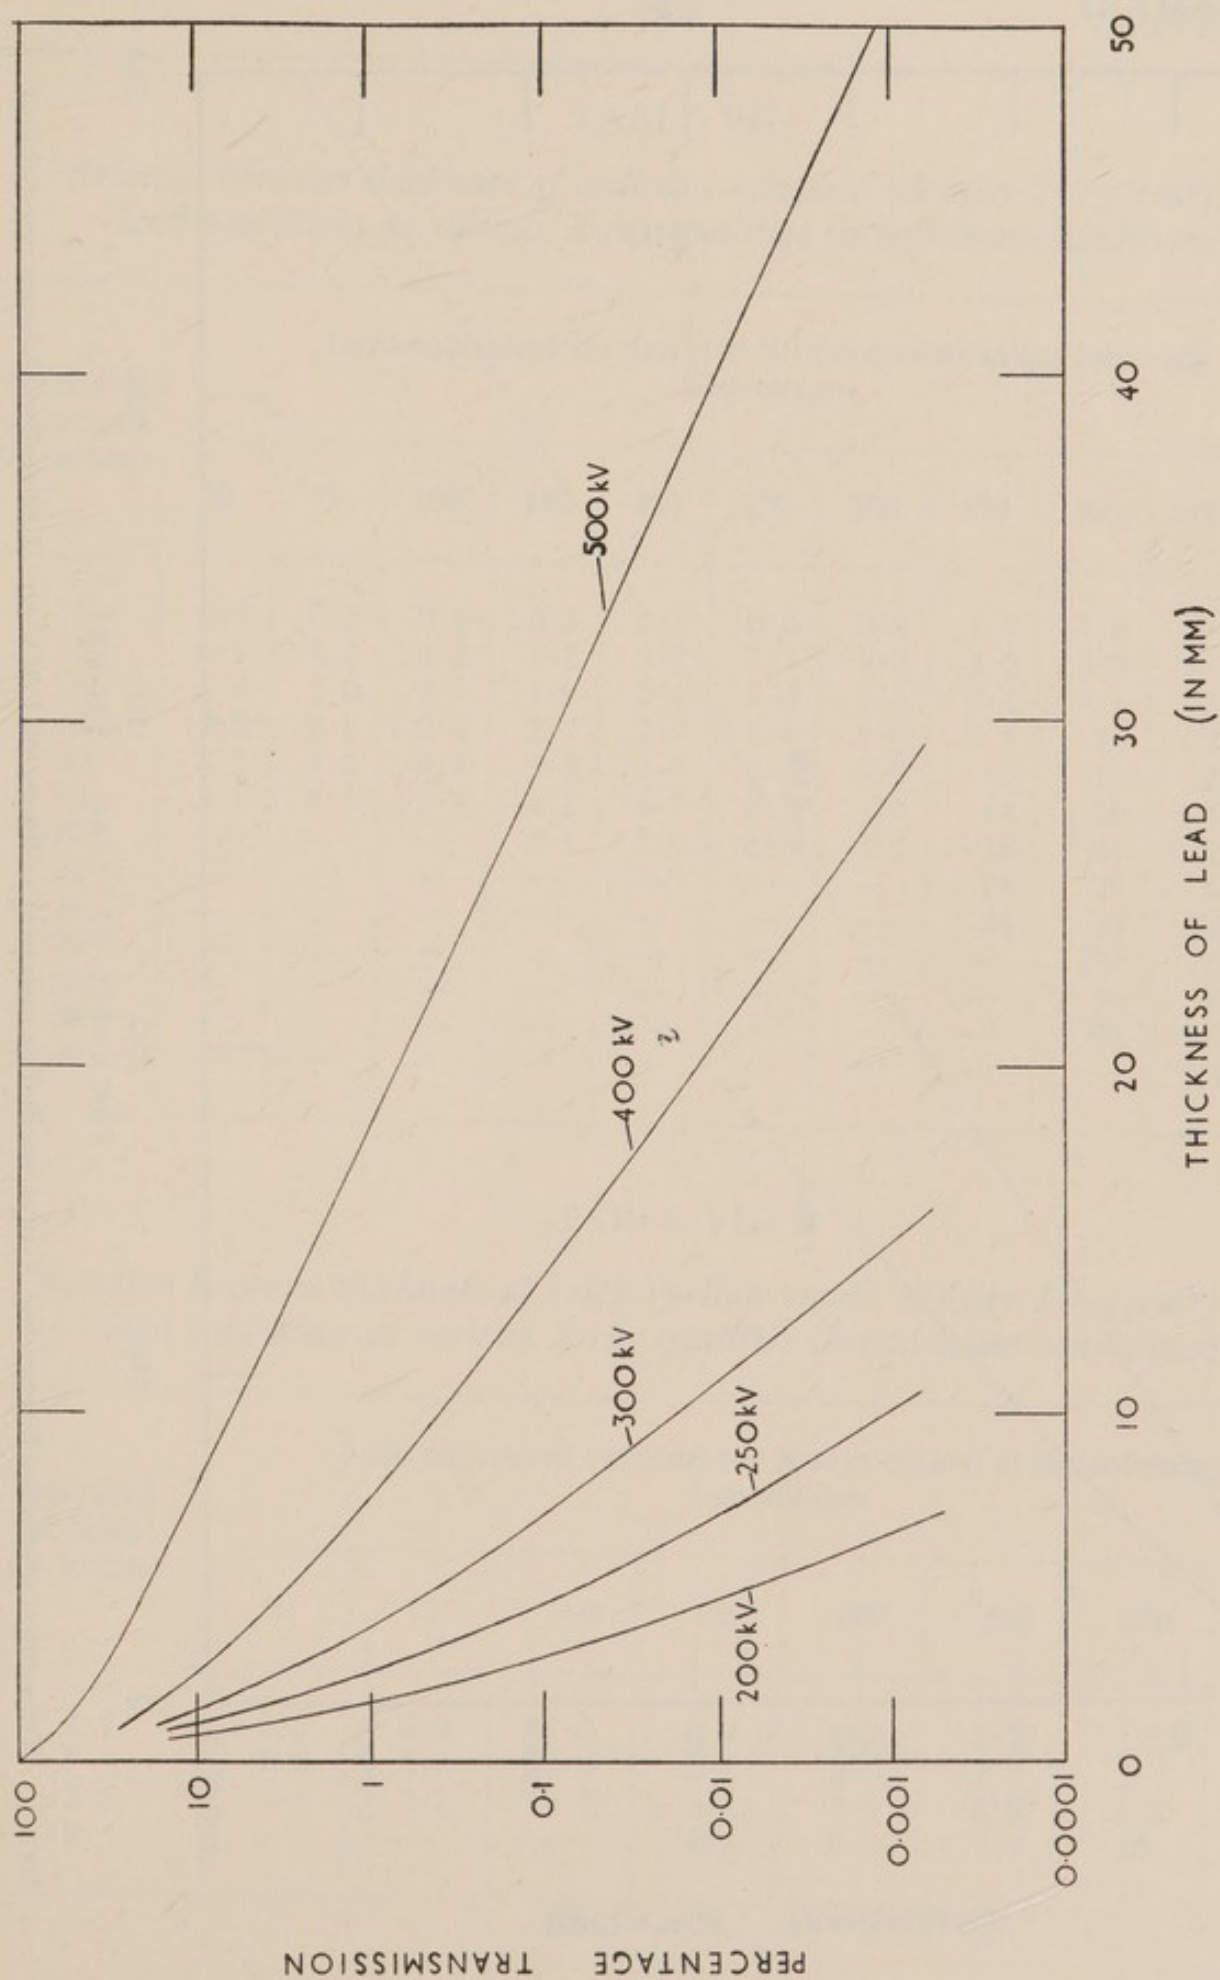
Transmission curves in lead for X-rays excited at various constant voltages between 200 kV and 500 kV (broad-beam conditions).
